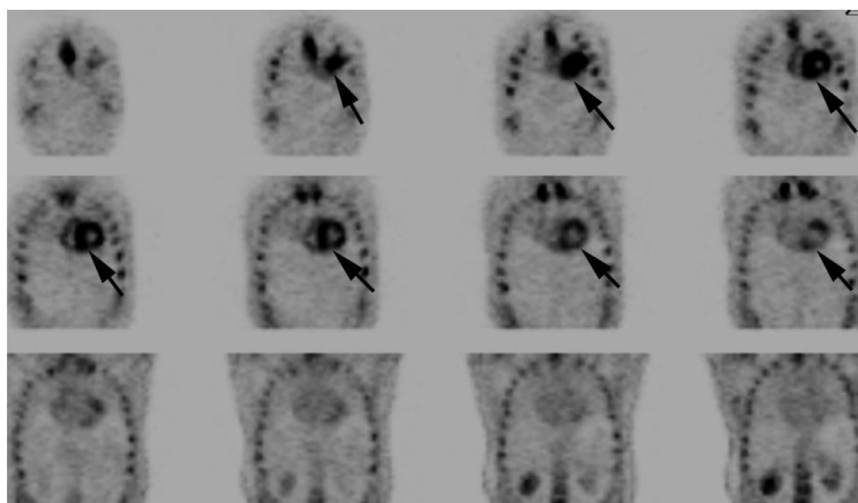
Selected coronal images corresponding to ^{99m}Tc -PYP single-photon emission computed tomography images confirmed the planar image findings of intense tracer uptake in the myocardium (arrows).
